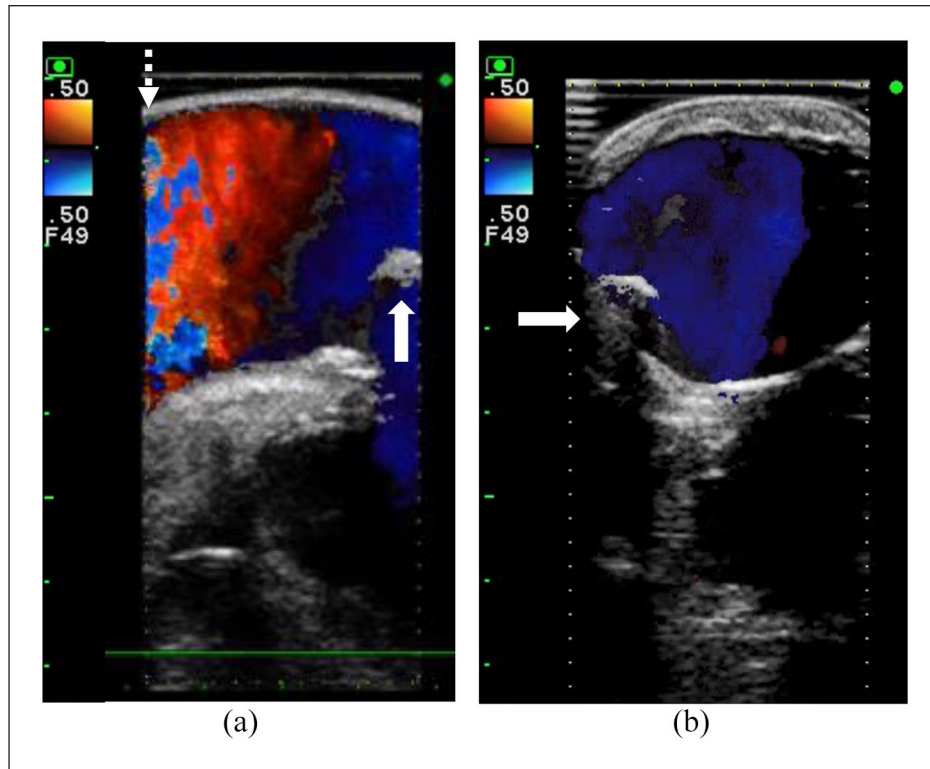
Epi-aortic echocardiography during reversed perfusion shows a mosaic pattern into the aortic root, indicating wall shear stress and the sandblast effect of the aortic wall (a). A mosaic pattern cannot be observed in the ascending aorta near the atheromatous plaque (arrow) (a and b).
